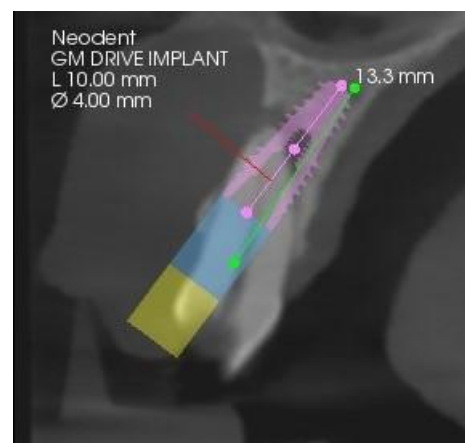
CBCT planning reveals labial access channel of the abutment
